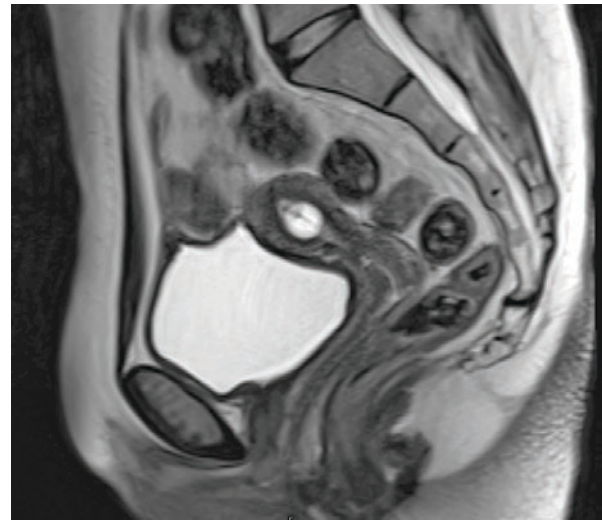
Sagittal T2-weighted image of the uterus demonstrating the catheter balloon within the uterine cavity.
